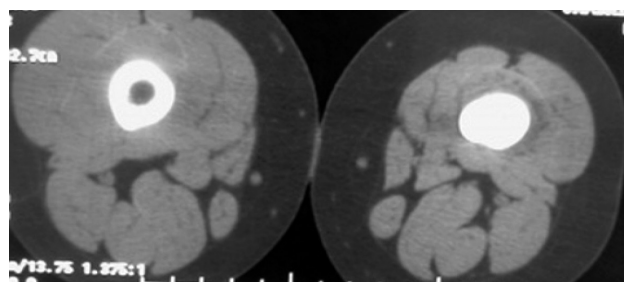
CT scan showing a notable sclerosis of distal diaphysis with muscular atrophic changes and mild heterogeneous density.
